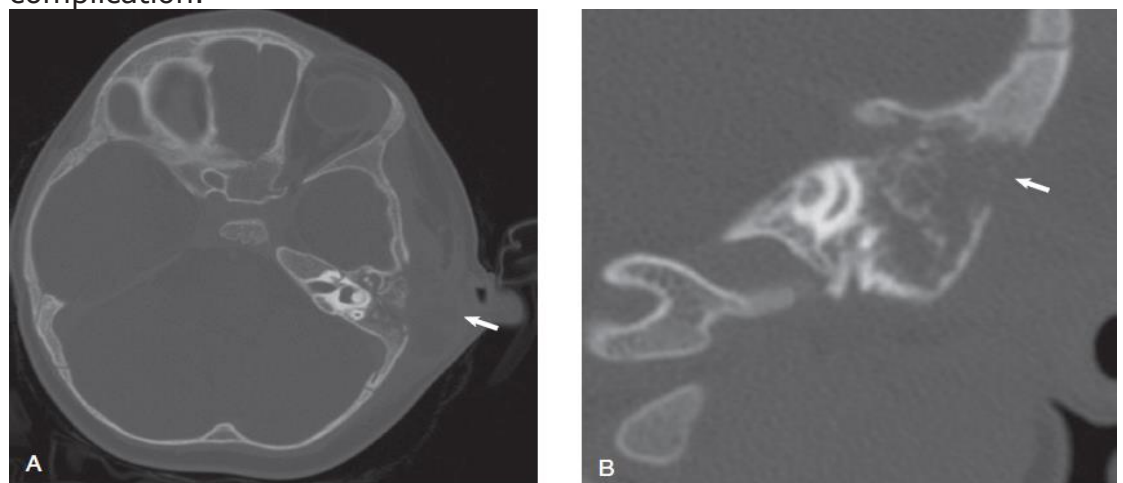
Axial (A) and coronal (B) temporal bone computed tomography scan shows opacification of the mastoid with loss of bony septa. Note the defect in cortical bone and postauricular fluid collection (arrows).
